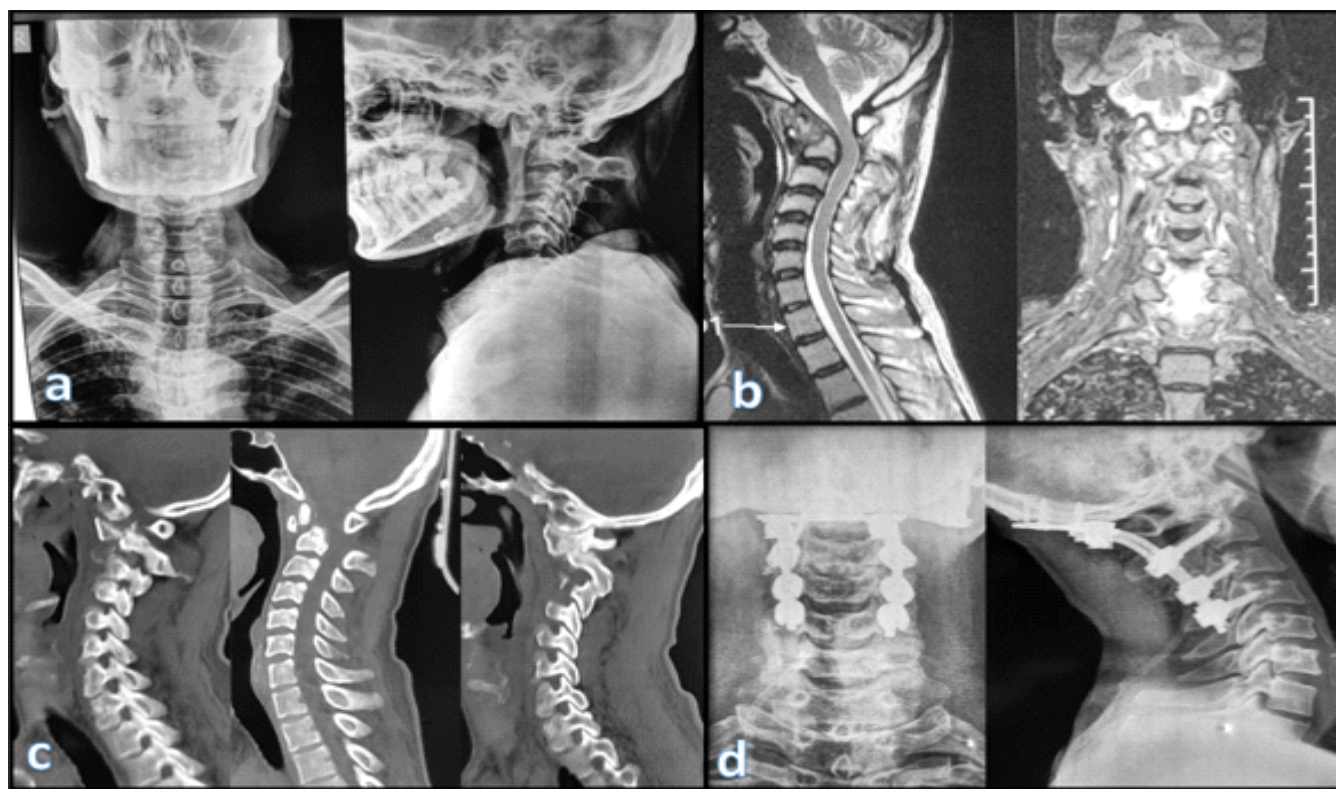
Radiological Evaluation of Infective C1-C2 Spondylodiscitis with Basilar Invagination Before and After Occipito-Cervical Fusion. (a) Preoperative anteroposterior and lateral cervical radiographs demonstrating craniocervical junction malalignment with atlantoaxial instability and features suggestive of basilar invagination. (b) Preoperative sagittal and coronal magnetic resonance imaging (MRI) demonstrating infective spondylodiscitis involving the C1-C2 articulation with associated soft tissue inflammation, cervicomedullary compression, and ventral brainstem indentation. (c) Preoperative sagittal computed tomography (CT) images demonstrating Osseous ligamentous destruction at the atlantoaxial complex, superior migration of the odontoid process, increased atlantodental interval, and altered clivo-axial alignment consistent with severe craniocervical instability. (d) Postoperative anteroposterior and lateral radiographs demonstrating satisfactory Occipito-cervical fixation extending from the occiput to C4 with restoration of Craniocervical alignment following posterior stabilization, foramen magnum decompression, and C1 posterior arch excision.
